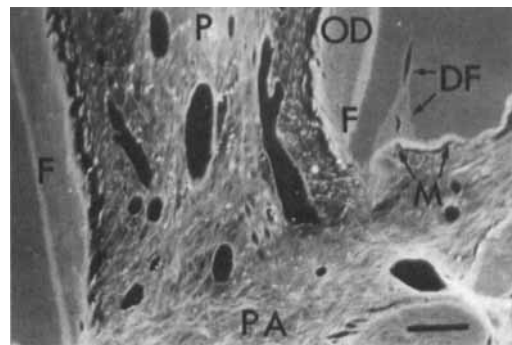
The apicoectomized dentinal root areas covered with hard-tissue matrix (M) 30 days after replantation. Dental fracture (DF) partly filled in with hard-tissue matrix. P = pulpal tissue; F = fluorescent band; OD = osteodentin; PA = periapical tissue. (Procion H8-BS label, ultraviolet light; bar = 100  $\mu$ m.)
